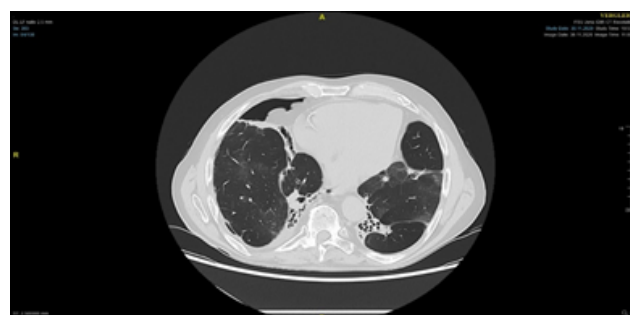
Contrast-enhanced chest CT on admission: ventral-basal pneumothorax in the right lung without signs of a tension component. Diffuse alveolar haemorrhage in the right lobe.
